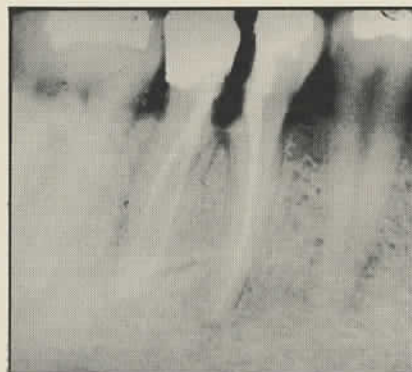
Gutta percha cone radiograph points in the furcation area, but curling towards the mesial root (arrow). In general, alveolar bone support appears favourable for tooth 36.
